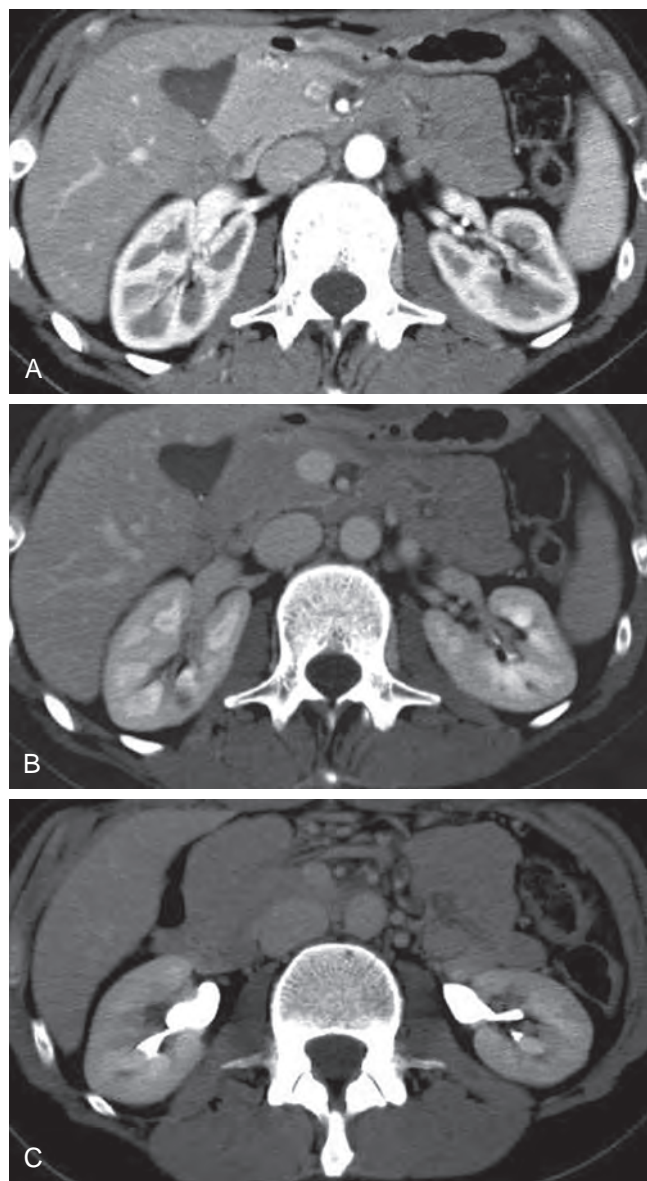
Computed tomography of normal renal parenchyma. A, The corticomedullary phase shows high contrast in the renal cortex after 30 to 70 seconds of contrast injection. B, The nephrographic phase shows renal cortex and medulla with equal enhancement after 80 to 120 seconds of contrast injection. C, The excretory phase shows the opacified urinary tract after more than 180 seconds. (From Quaia E, Martingano P, Cavallaro M, et al. Normal radiological anatomy and anatomical variants of the kidney. In: Quaia E, editor. Radiological imaging of the kidney (medical radiology/diagnostic imaging). New York: Springer; 2011. p. 17–78.)
